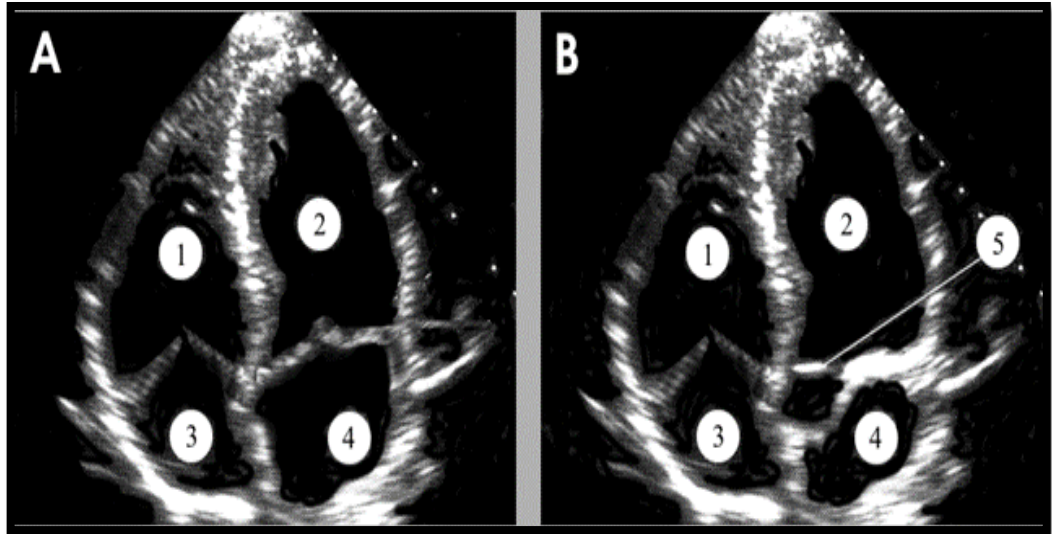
Apical 4-chamber (A) and 5-chamber (B) 2-D ultrasound images. Right ventricle (1), left ventricle (2), right atrium (3), left atrium (4), aortic valve (5).
